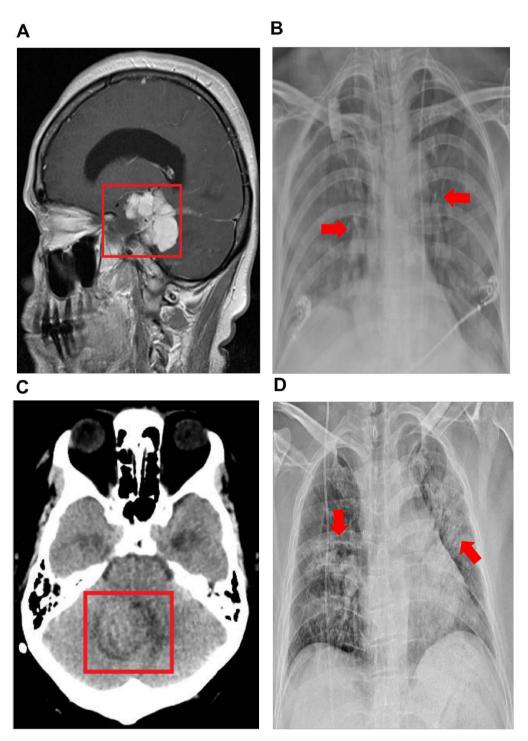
Cranial and chest CT of patients with a brain tumor and COVID-19. (A) Case 1 magnetic resonance T1 sequence contrasted sagittal section petroclival lesion extending to a protuberance, enhancing the contrast medium compatible with meningioma. (B) Case 1 chest computed tomography (CT) with data suggestive of SARS-CoV-2 pneumonia. (C) Case 2 simple CT scan of the skull in coronal section showing lesion to the cerebellar vermis and right cerebellar hemisphere causing hydrocephalus. (D) Chest CT at admission showing severe pneumonia of Case 2.
